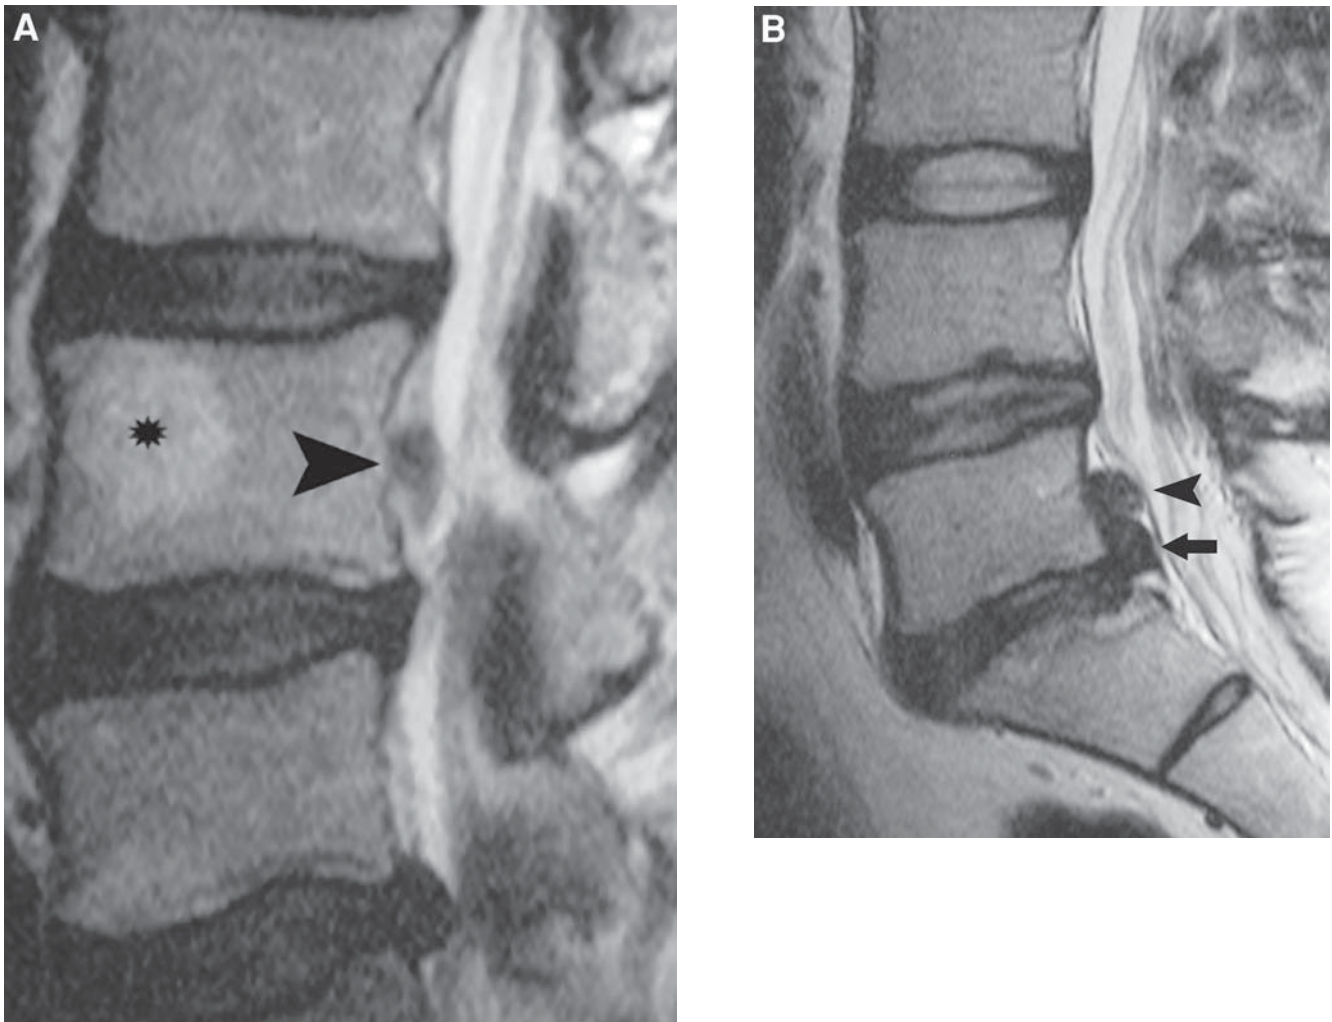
(A) Sagittal MRI showing a disc herniation (sequestered disc). Incidental note is made of a vertebral body hemangioma (*star*). (B) Sagittal MRI showing a large disc herniation at L5–S1 with the disc material tracking posterior to the L5 vertebral body.
